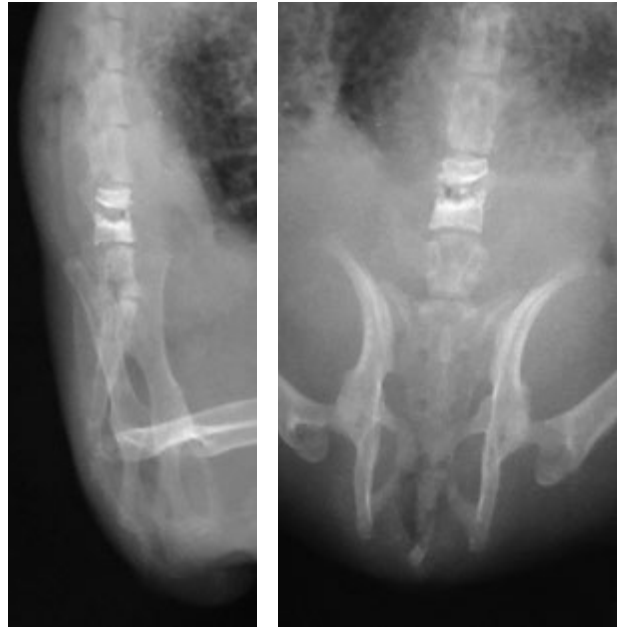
X-ray of the spine. Contact destruction of vertebrae
